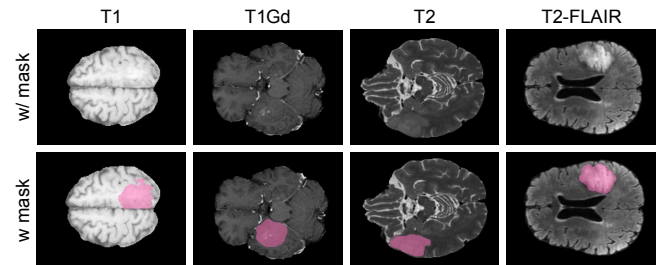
MRI modalities. Examples of tumour visualization in which each column represents a different MRI modality. In these cases, the full tumour extension is not visible in any single modality, highlighting the necessity of leveraging all of them to accurately predict and segment the tumour region. The top row shows the raw MRI images, while the bottom one includes the ground-truth tumour region.
